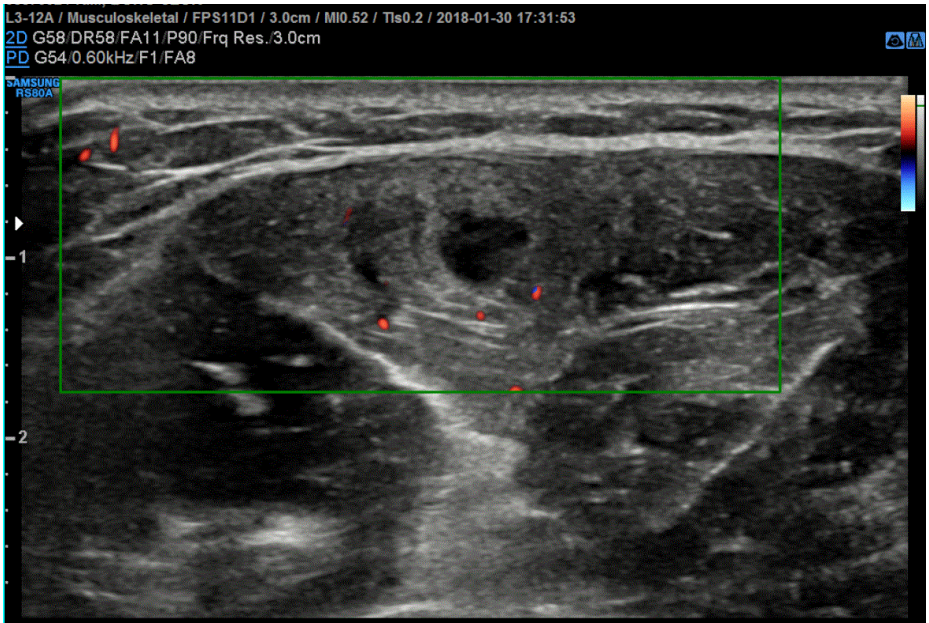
Trasverse view of right forearm of ultrasonograhic exam : This show multiple hypoechoic echo-texture lesion suspected of hematoma in the flexor muscle group of forearm
